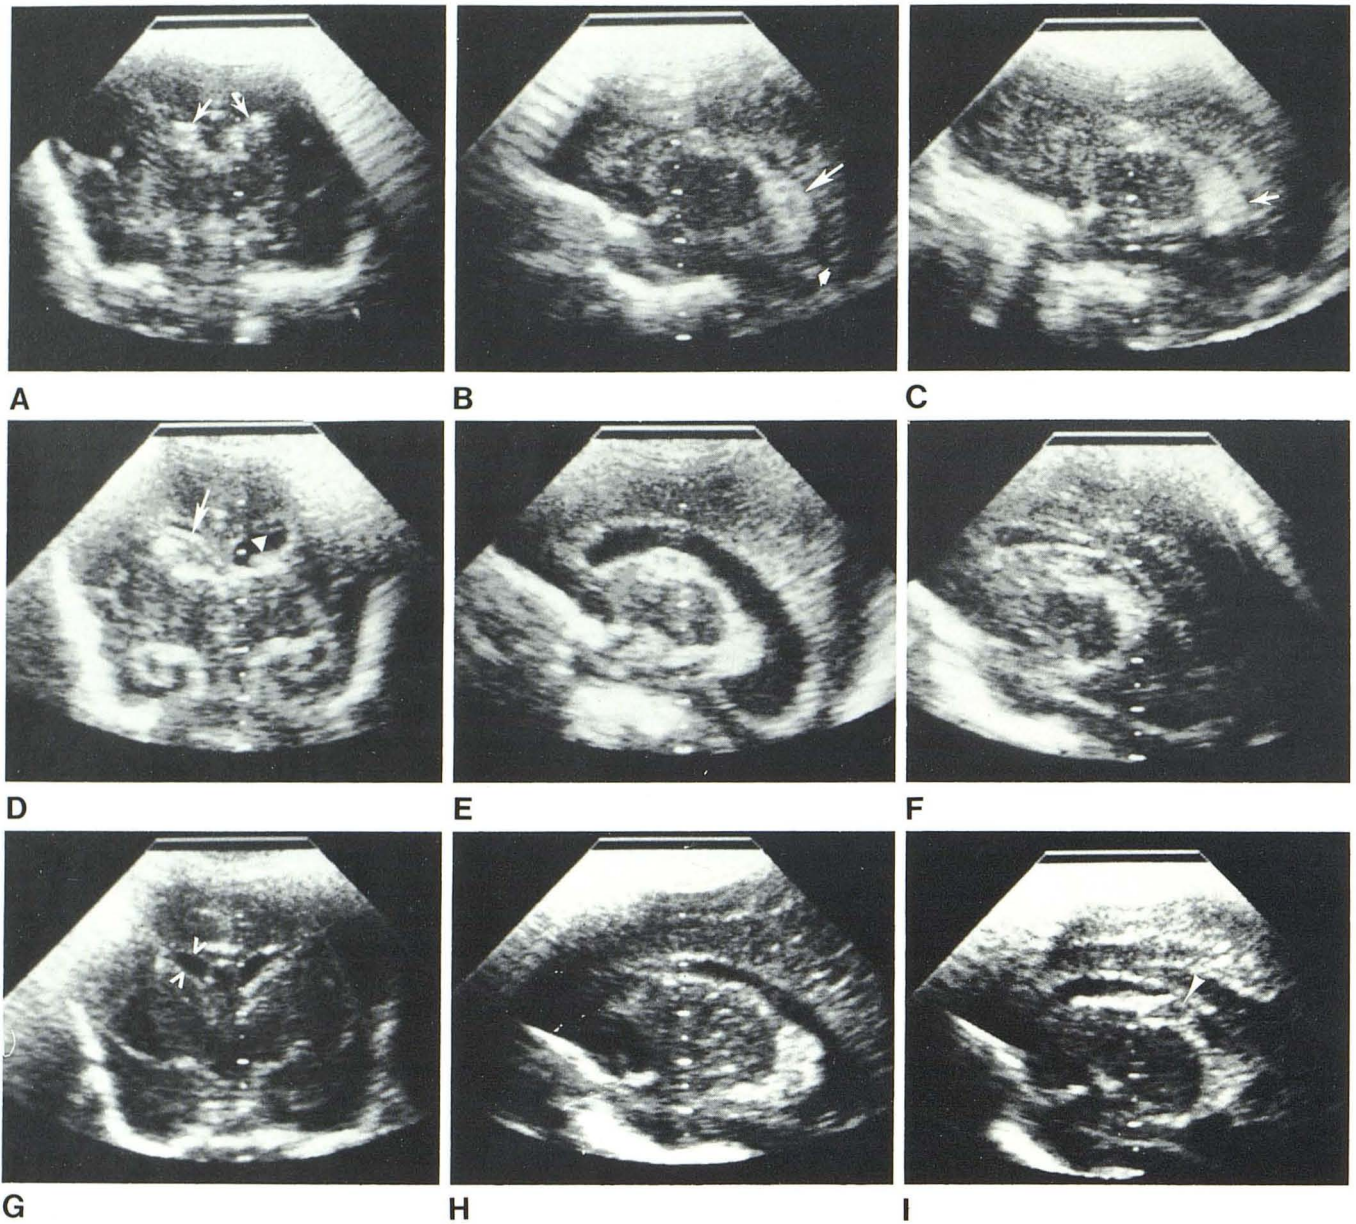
SEH/IVH leading to moderate ventricular dilatation with spontaneous resolution. A–C, Day 3. A, Coronal sonogram. Bilateral IVH (arrows) in lateral ventricles. Centimeter gradations are projected in center of image. B, Modified parasagittal sonogram. SEH/IVH (large arrow) with clot in right occipital horn (small arrow). C, Same as B on left showing SEH/IVH (arrow). D–F, Day 13. D, Coronal sonogram. Moderate dilatation, clot in right lateral ventricle (arrow) and left SEH (arrowhead). E, Modified sagittal sonogram.
